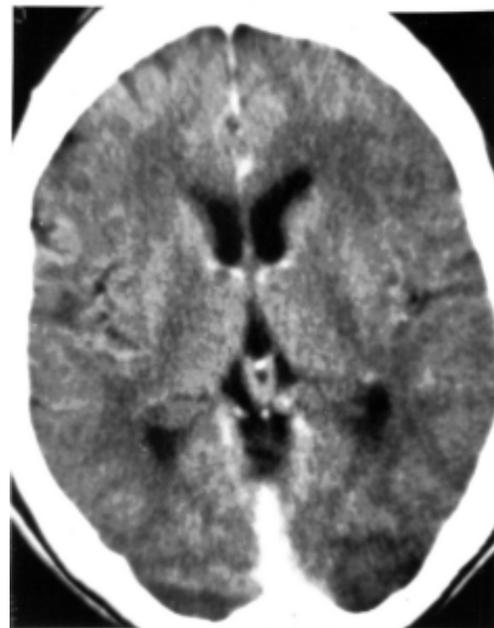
Preoperative CT scan with contrast, showing slight dilatation in the left frontal horn of the lateral ventricles, in a 75-year-old woman with mild AD.
